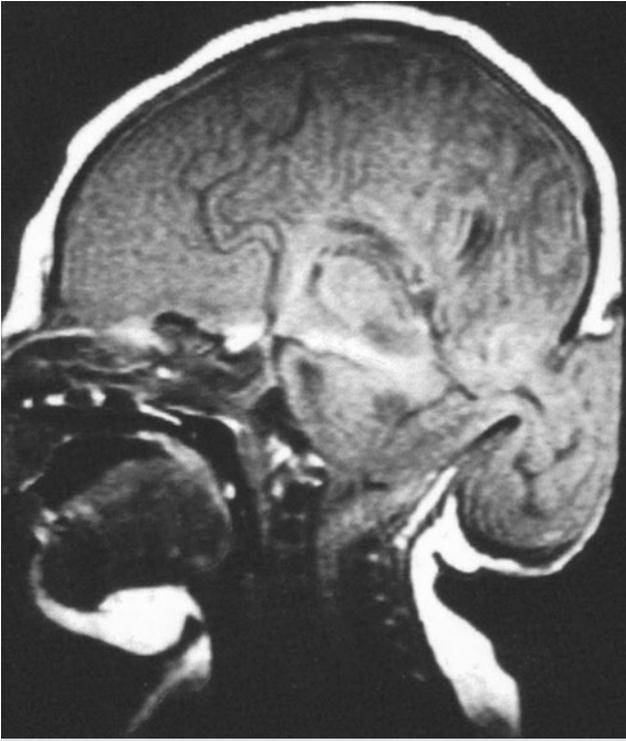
Sagittal magnetic resonance image demonstrates a large amount of herniating cerebellar tissue, along with occipital lobe, through a small cranial defect. Coronal magnetic resonance image showing a large meningocele associated with the encephalocele in.
